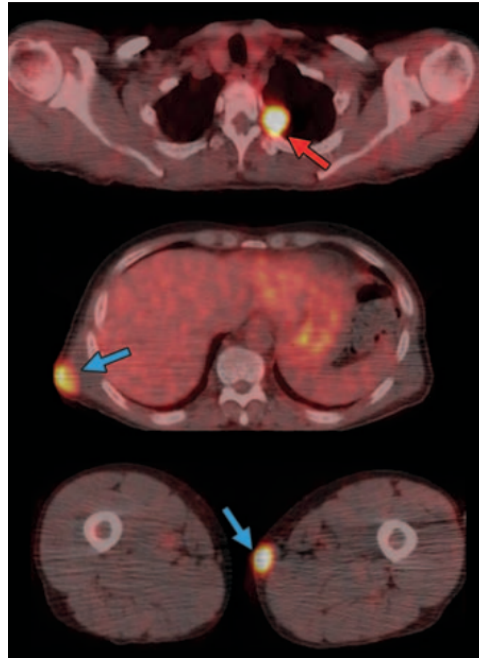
MM relapse with cutaneous and pleural plasmacytomas in a 49-year-old man, who initially presented with isolated C5 vertebral involvement and was treated with radiation therapy and systemic chemotherapy. With apparent biochemical and clinical response, the patient was scheduled for allogenic bone marrow transplantation. Restaging axial fused PET/CT images show 18F-FDG avid pleural plasmacytoma (red arrow) and several cutaneous plasmacytomas (blue arrows), compatible with active disease. No FDG-avid lesion was noted at the primary site (C5 vertebra). The patient was subsequently started on systemic chemotherapy. [2]
